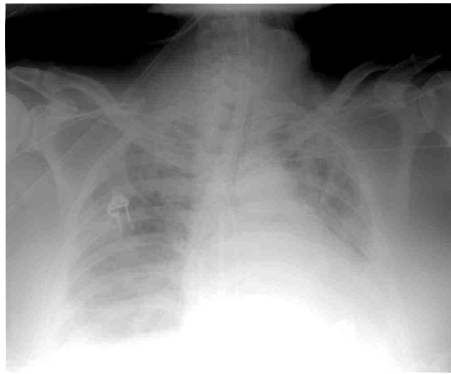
Original ICU chest X-ray image.
